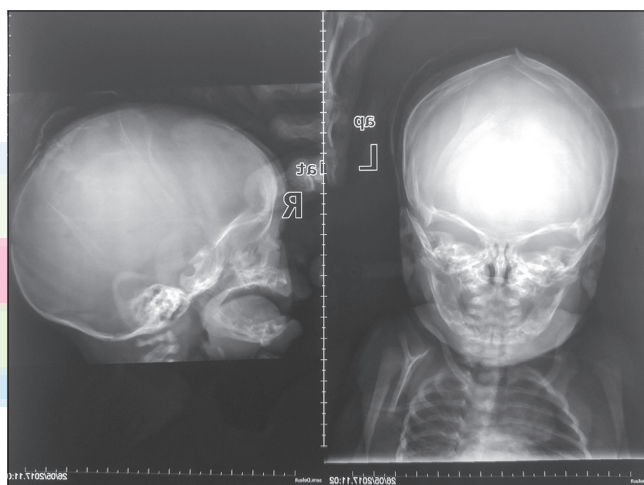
Skull X-ray picture of a newborn baby whose depressed skull fracture corrected surgically
